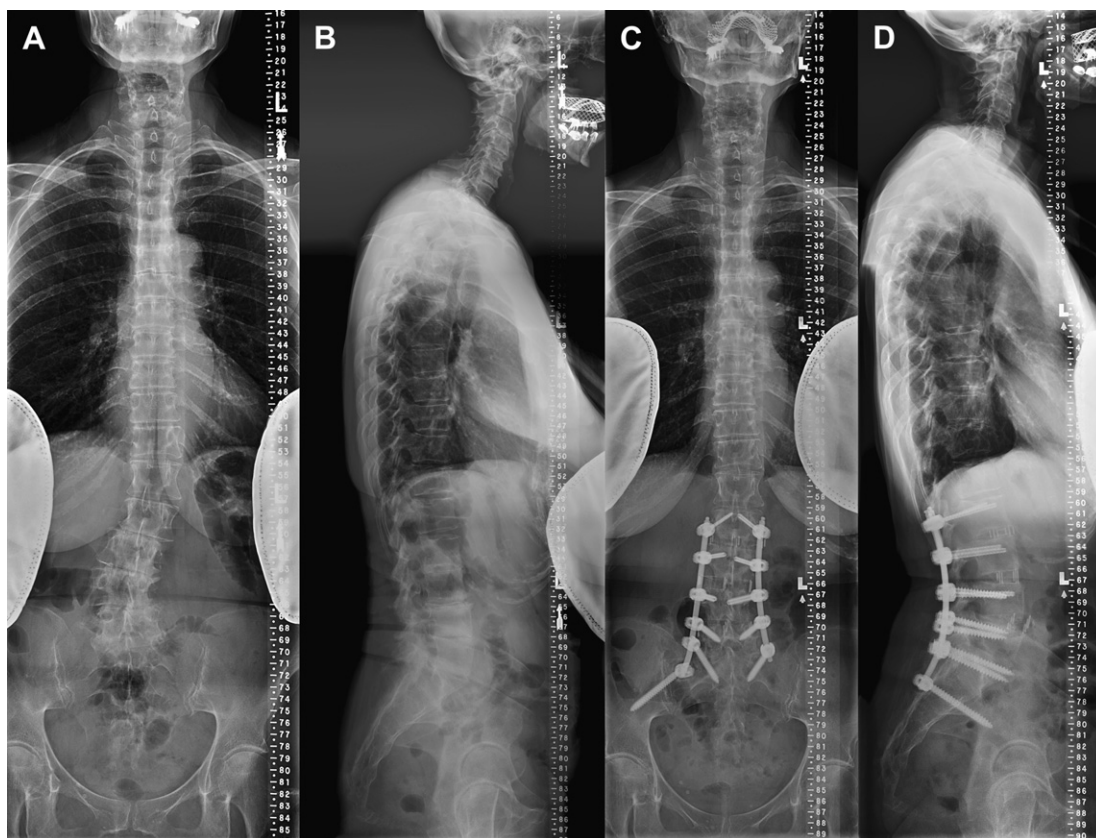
A 67-year-old woman presented with low back and bilateral radicular leg pain. (A, B) Her preoperative 91.44-cm (36-in) radiographs revealed L2 to 3 lateral listhesis, an SVA of 4.3 cm, and a lumbar lordosis of 27°. (C, D) Postoperative 91.44-cm (36-in) radiographs after an L2 to L5 LIF and an L2 to the sacrum posterior MIS spinal fusion with a right iliac screw fixation (MiSLAT IV treatment).
